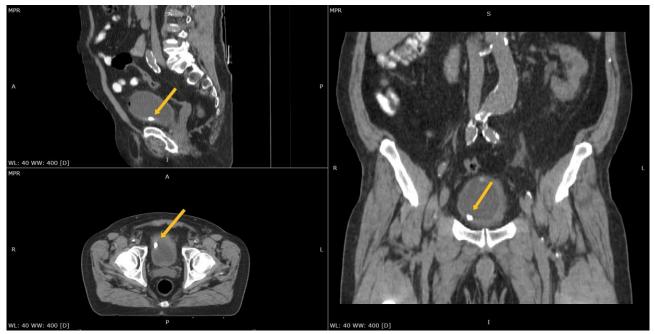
BioXmark[®] in bladder, Planning CT Scan
